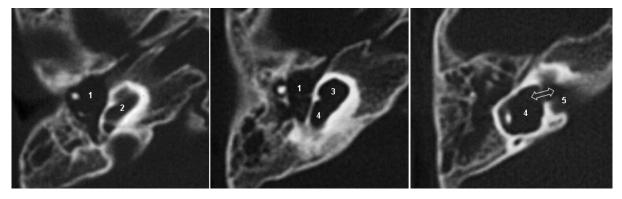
Representative scans of the preoperative CT about the right middle and inner ear. 1: tympanic cavity; 2: unusually wide proximal portion of the basal turn; 3: undifferentiated distal part of the cochlea; 4: enormously wide vestibule, partially incorporating the horizontal semicircular canal; 5: pathologically wide inner auditory canal; ↔: perilymph-CSF communication through the deficient bony partition between labyrinth and IAC
